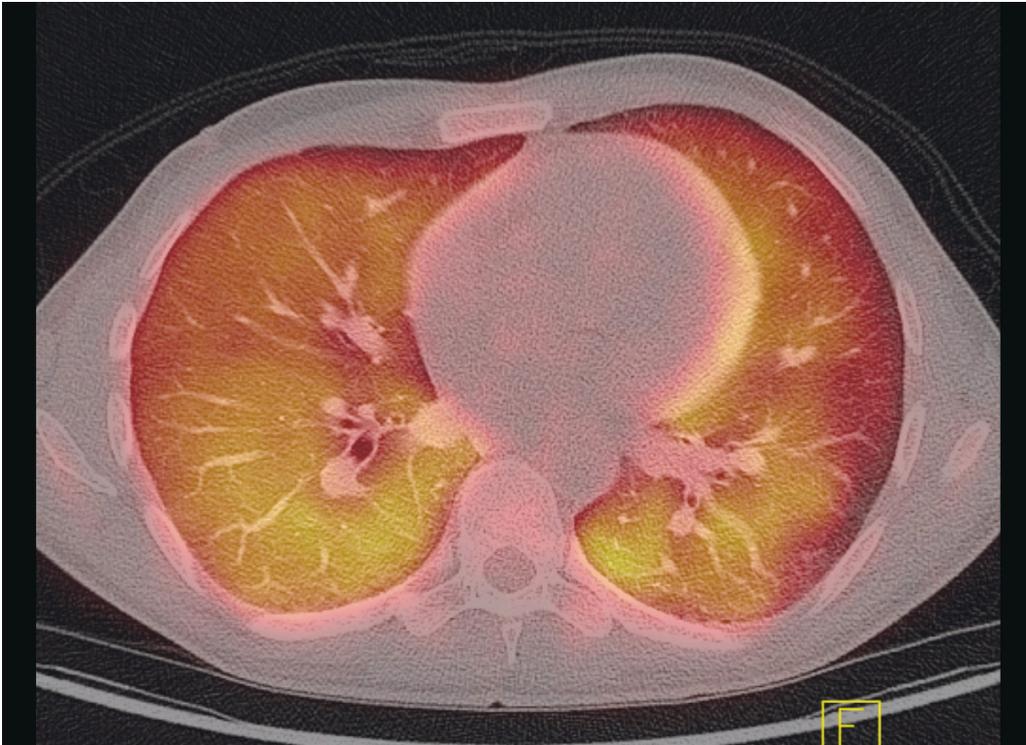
PET-CT showed strong, diffuse uptake of ^{18}F -fluorodeoxyglucose in the lung parenchyma (yellow).
